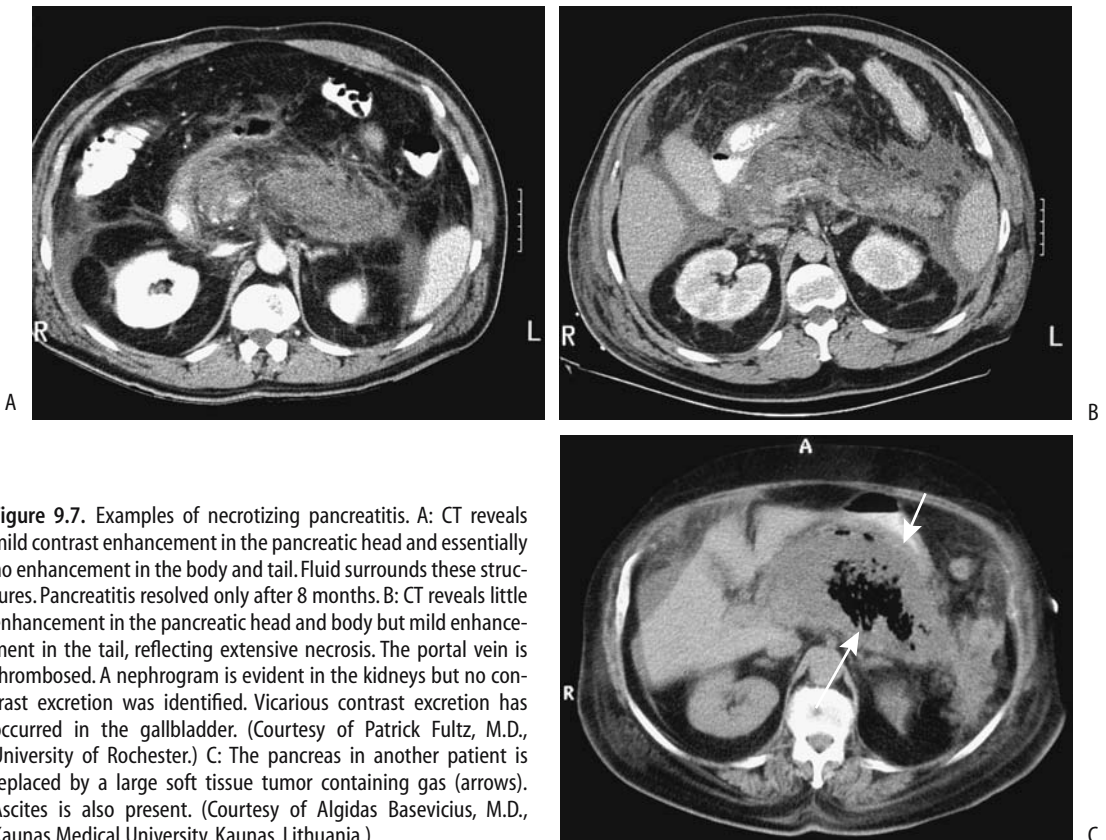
Examples of necrotizing pancreatitis. A: CT reveals mild contrast enhancement in the pancreatic head and essentially no enhancement in the body and tail. Fluid surrounds these structures. Pancreatitis resolved only after 8 months. B: CT reveals little enhancement in the pancreatic head and body but mild enhancement in the tail, reflecting extensive necrosis. The portal vein is thrombosed. A nephrogram is evident in the kidneys but no contrast excretion was identified. Vicarious contrast excretion has occurred in the gallbladder. (Courtesy of Patrick Fultz, M.D., University of Rochester.) C: The pancreas in another patient is replaced by a large soft tissue tumor containing gas (arrows). Ascites is also present. (Courtesy of Algidas Basevicius, M.D., Kaunas Medical University, Kaunas, Lithuania.)
